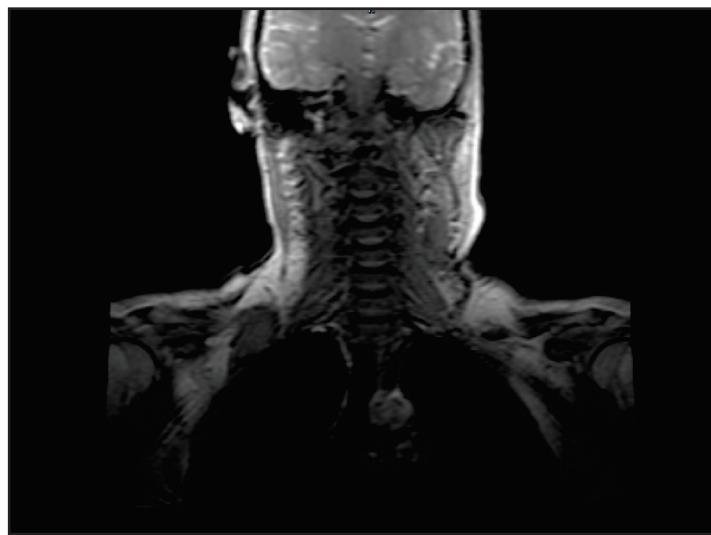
Results of MRI of the brain, frontal projection: no data for recurrence were revealed in a 63-year-old patient diagnosed with Ameloblastoma of the lower jaw on the right. Recurrence.
